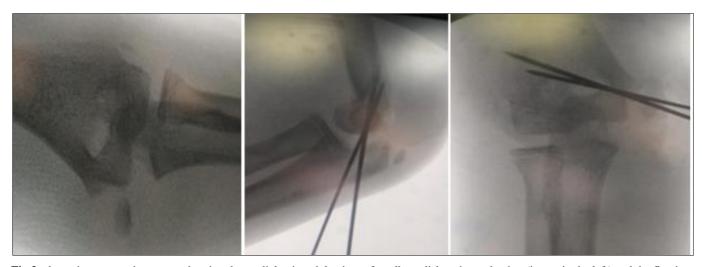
shows intra-operative x-rays showing the medial epicondyle piece after elbow dislocation reduction (image in the left) and the fixation with k-wires.
